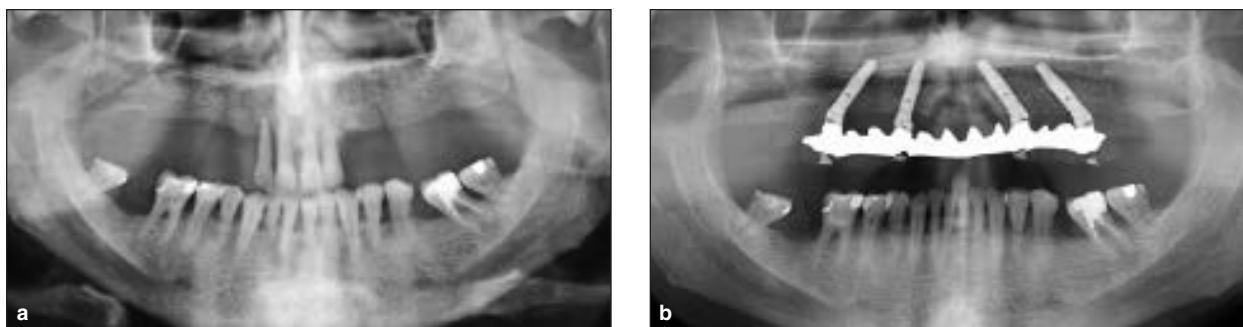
Panoramic radiographs of patient (a) before treatment and (b) after 6 years of function with the Columbus Bridge.
